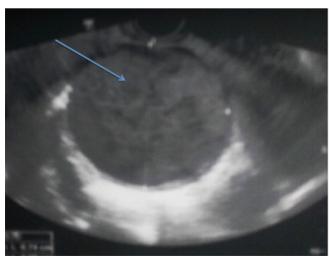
Abdominal and pelvic ultrasound examination showing a pelvic mass with solid and cystic component making 10 cm long axis.
